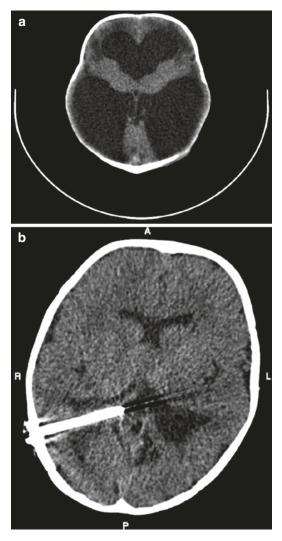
Axial CT images demonstrating ventriculomegaly (a). The hydrocephalus was treated with insertion of ventriculoperitoneal shunt with resolution of ventriculomegaly as demonstrated on the CT scan obtained 1 year after shunt insertion (b)
